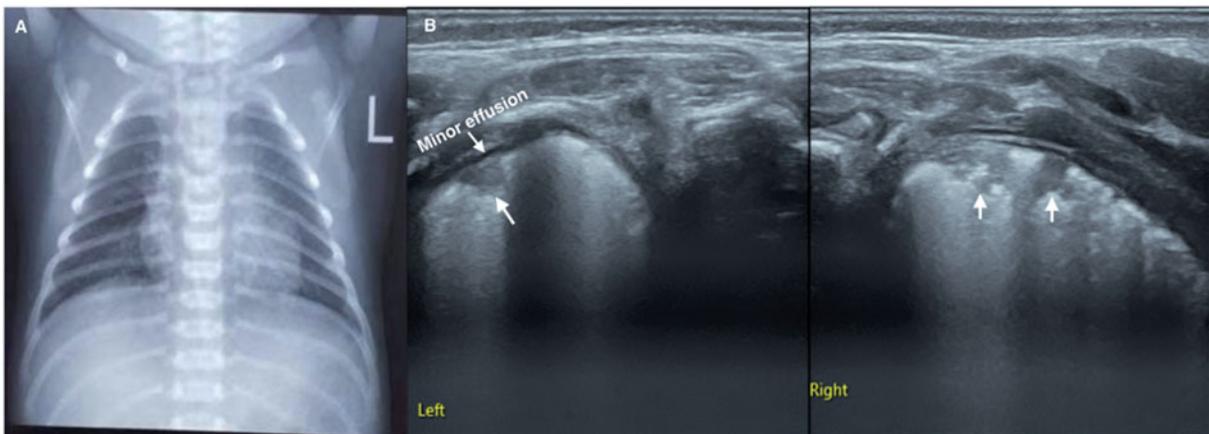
LUS is superior to chest x-ray in diagnosing pneumonia. A 13-day baby was admitted to the hospital because of cough and fever with moist rale in bilateral lungs on auscultation. Blood tests showed an increased white blood cell counts and C-reactive protein. No abnormality findings on chest X-ray examination (A), while the LUS (B) showed that significant subpleural focal lung consolidation in both lungs. In addition, a small amount of pleural effusion was seen in the left thoracic cavity, which was consistent with the LUS imaging characteristics of pneumonia.
